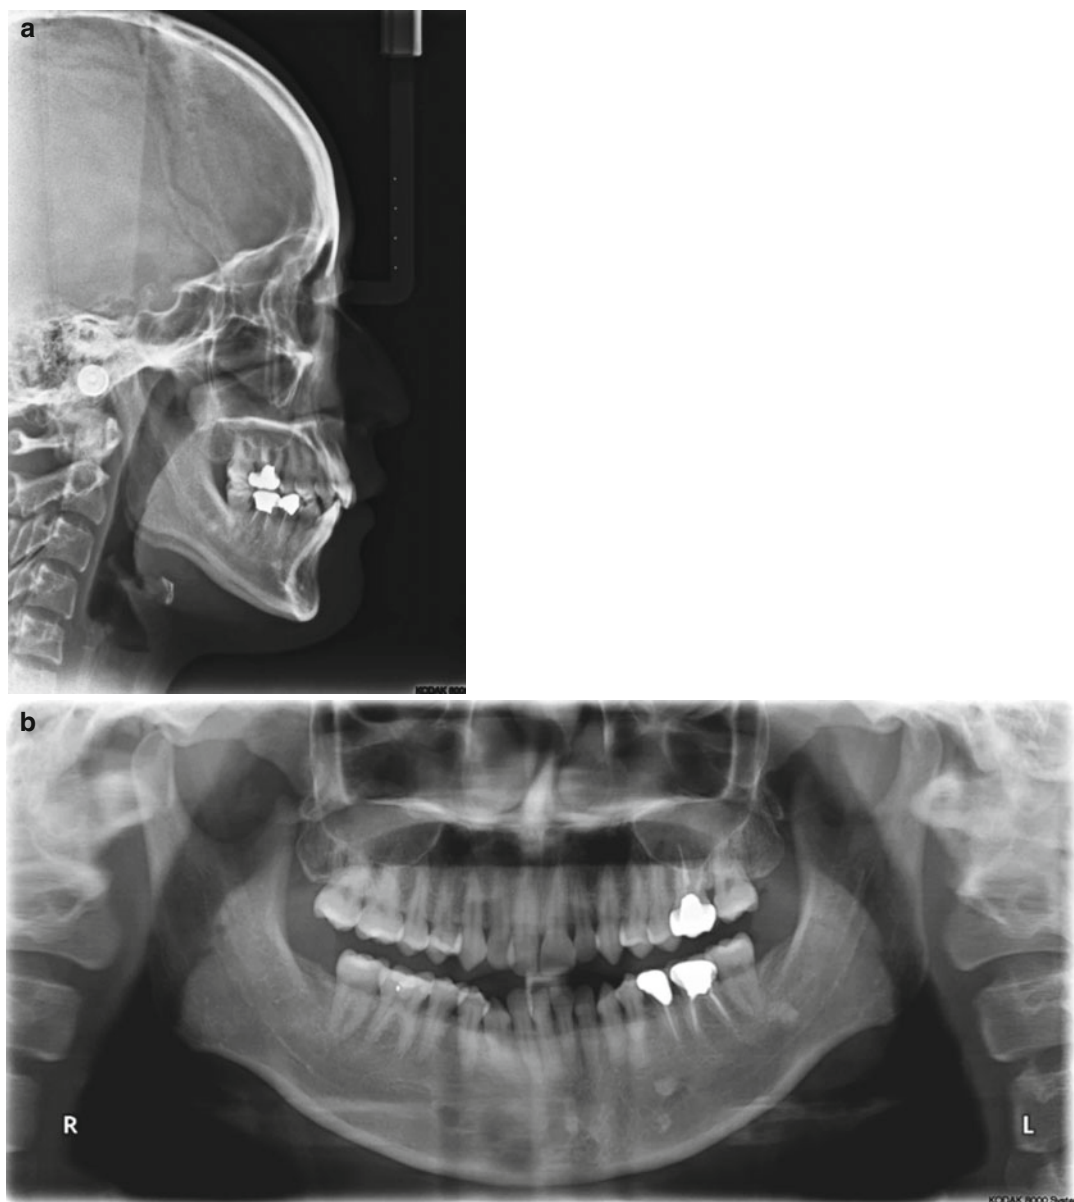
Initial lateral cephalogram (a) and panoramic radiograph (b)
